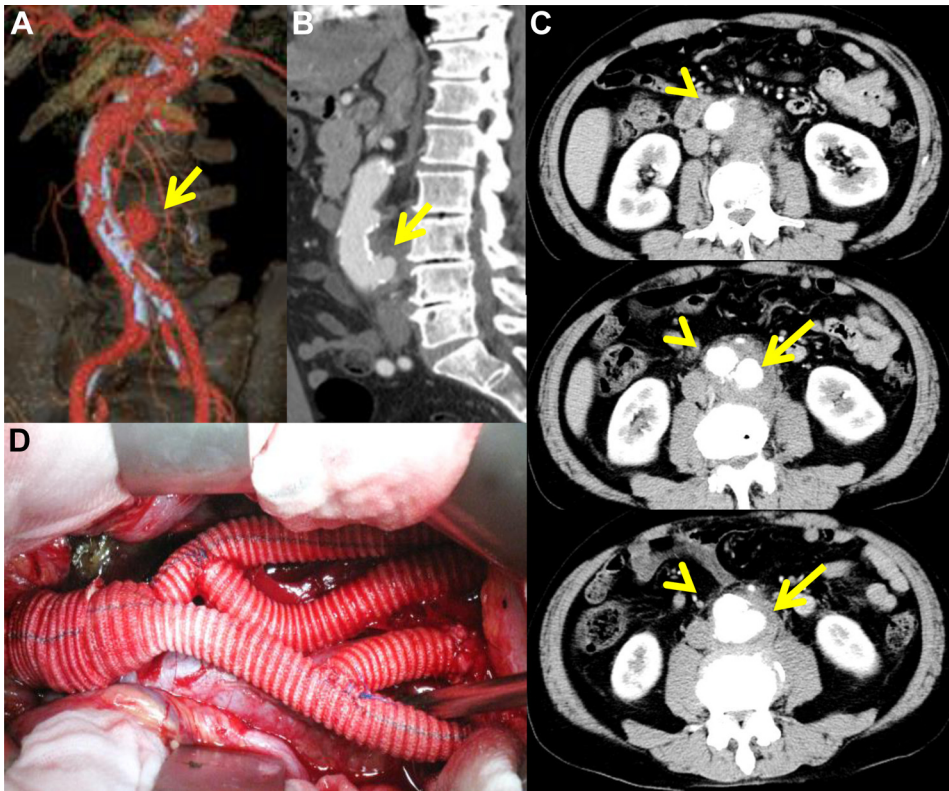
Abdominal contrast-enhanced computed tomography (CECT) and gross appearance of J-Graft. (A) A coronal image of the three-dimensional vascular reconstruction, (B) a sagittal image of CECT, (C) Axial images of CECT, and (D) rifampicin (RFP)-bonded J-Graft after anastomosis. Arrow: infected aneurysm, Arrowhead: true lumen.
